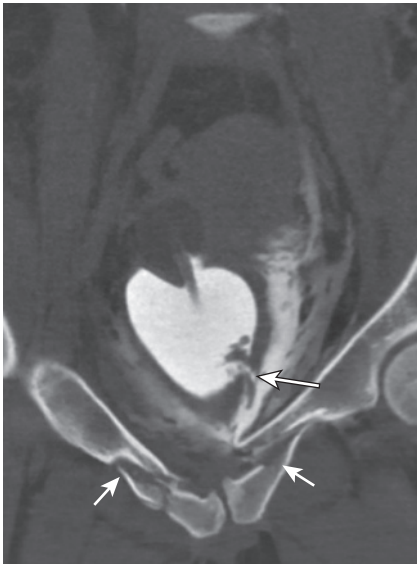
Coronal computed tomography of the pelvis with contrast injected via an in-dwelling catheter demonstrates extravasation (*long arrow*) from the bladder into the extra-peritoneal space, complicating multiple pelvic fractures (*short arrows*).
